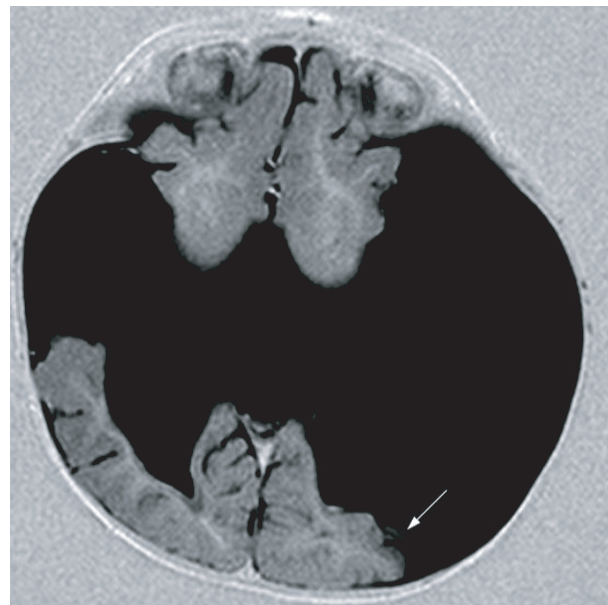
MRI images shows Polymicrogyric-dysplastic gray-matter surrounding the clefts bilaterally (arrow).
